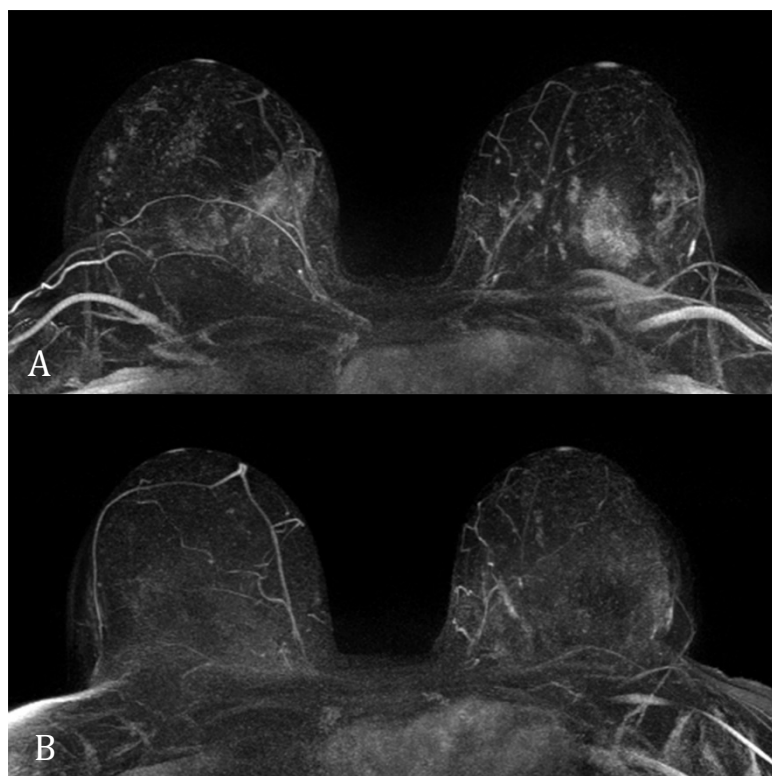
25-year-old asymptomatic female with known BRCA1 mutation entering the high-risk surveillance program with MRI. The patient is on oral contraceptives at the initial screening MRI exam in the program (A) showing strong BPE with asymmetric, multifocal distribution. Six-month short-term follow-up exam after discontinuation of oral contraception (B) with almost complete resolution of the hormone-induced changes in the prior exam. In both cases, the second dynamic sequence obtained in the second minute after contrast administration is shown. Remaining subtle changes in the left breast were stable on further follow-up and proved to be benign (fibrosis and blunt duct adenosis) on bilateral prophylactic mastectomy performed 3 years later.
